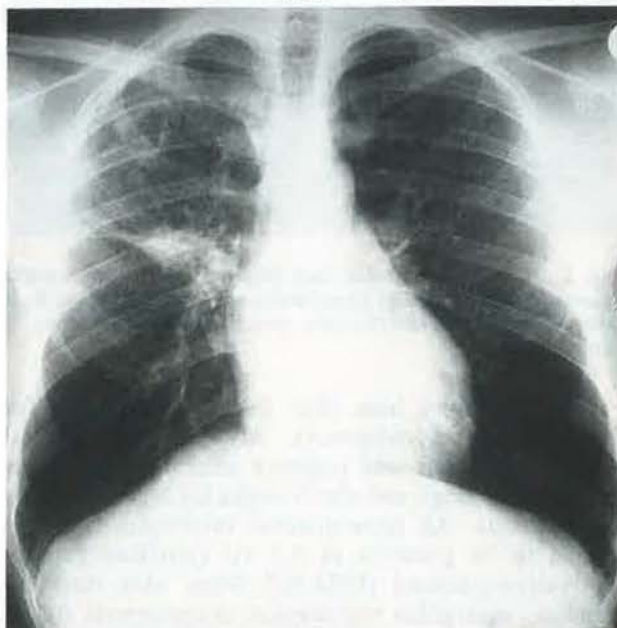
Posteroanterior chest X-ray on admission showing a dense infiltrate on the upper right hilar pole, a slightly diffuse interstitial infiltrate in the upper right lobe and a cavernous lesion under the clavicle.
